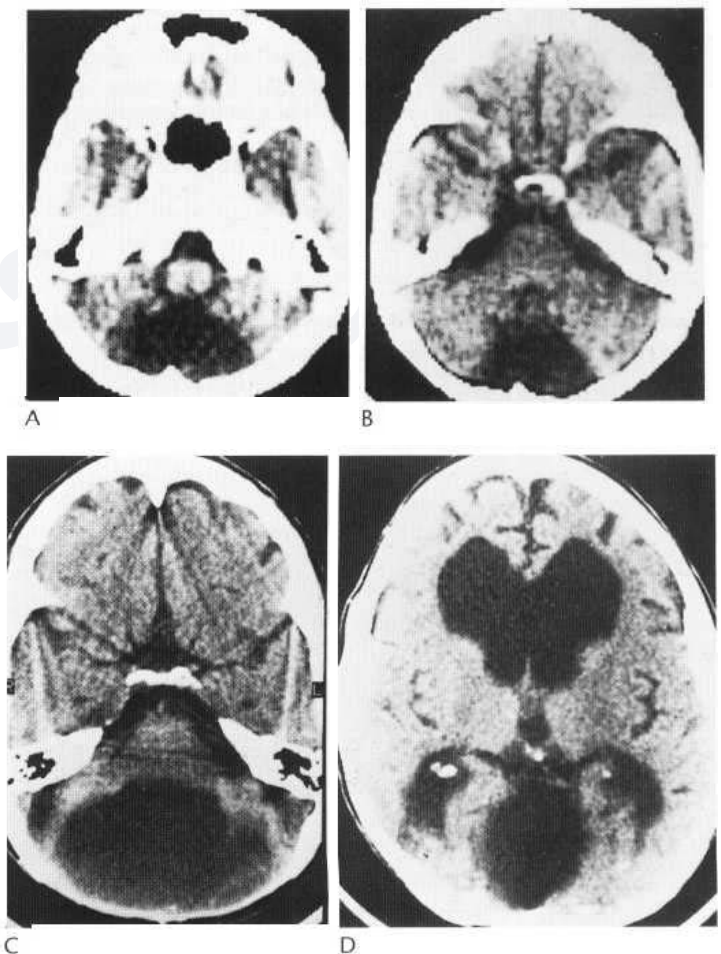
(A-D), Dandy-Walker syndrome shown by CT.
